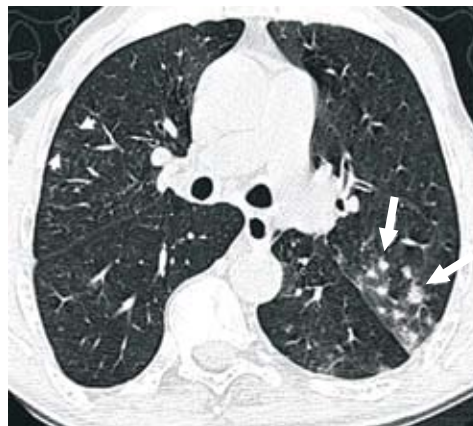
CT at the subcarinal level in an 18 year old male patient with FD shows multiple ill-defined lung nodules at the posterior aspect of the left upper lobe (arrows), representing small airways wall thickening or mucous plugging. Mild peripheral bronchiectasis is seen in the right upper lobe (arrowheads). Note the mild scoliosis.
